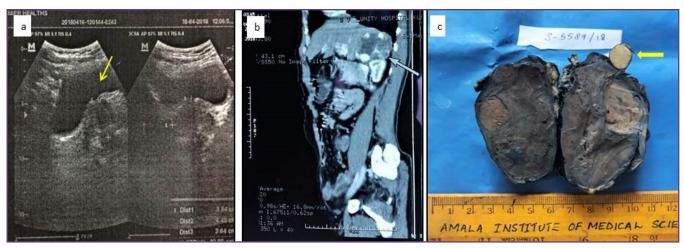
(a): USG Abdomen showing a well defined round hypoechoic mass lesion (yellow arrow) in right suprarenal region. (b): CT scan showing a heterogeneous lesion in the right adrenal gland (blue arrow). (c): Nodular mass measuring 8x5x3.5cm. Cut section showed a capsulated growth with a grey brown to tan cut surface interspersed with areas of haemorrhage and tiny cystic spaces. Another well defined yellow nodule measuring 1.3x1.2x1 cm was also noted (yellow arrow).
